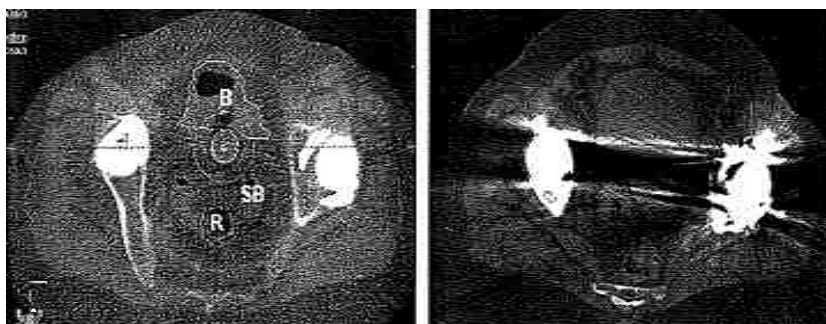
CT scans of a cervical ICBT T&O patient with hip prostheses with (A) a MVCT scanner and (B) a kVCT scanner. It is noted that in image (A), MV energy, the scan quality was sufficient for physician organ segmentation of the rectum (R), small bowel/sigmoid colon (SB) and the bladder (B). (Korol, et al., 2010)
